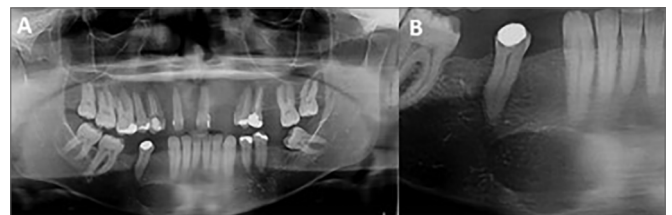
Panoramic radiograph. (A) Unilocular radiolucency beneath the roots of teeth 26 to 29. (B) Close-up view of the right mental region.
